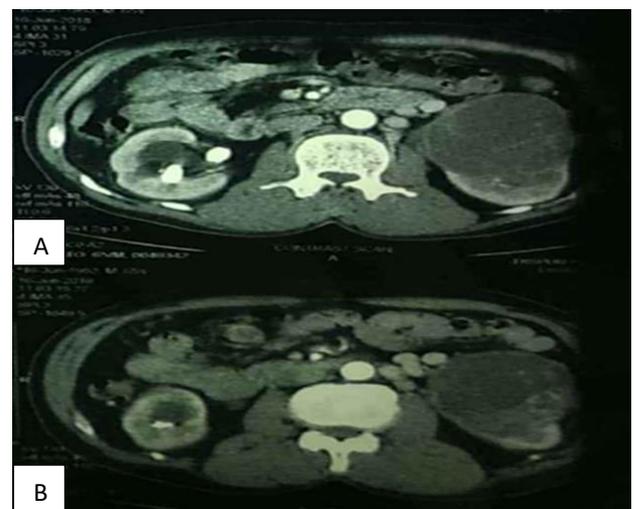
Contrast CT abdomen.
